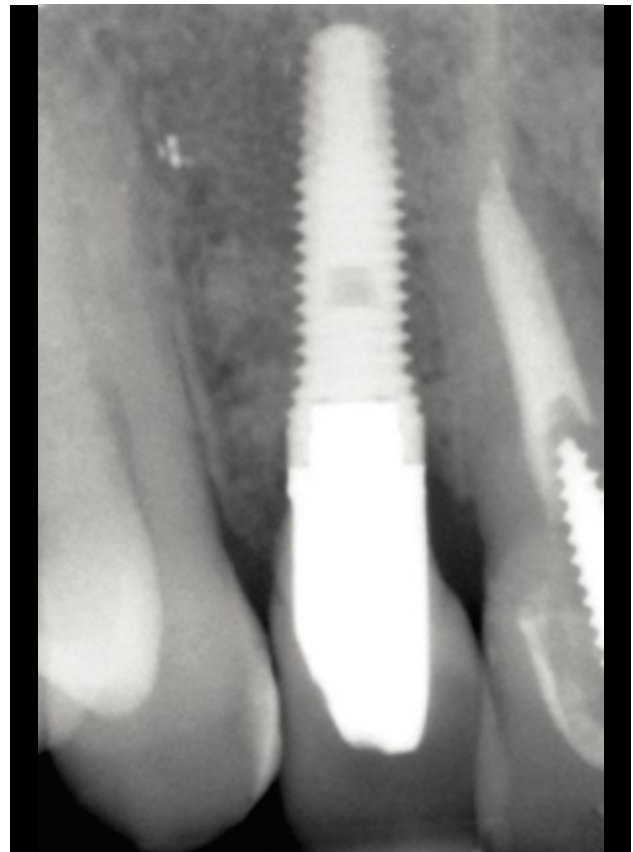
Follow-up radiography after 8 years, where the obtained result is maintained.
